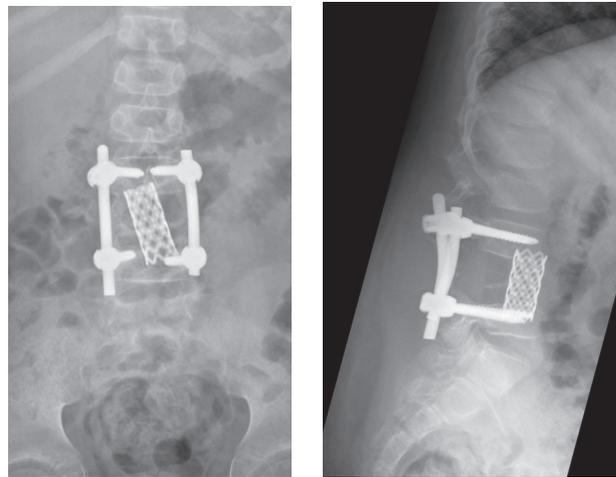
Second Postoperative X-rays
